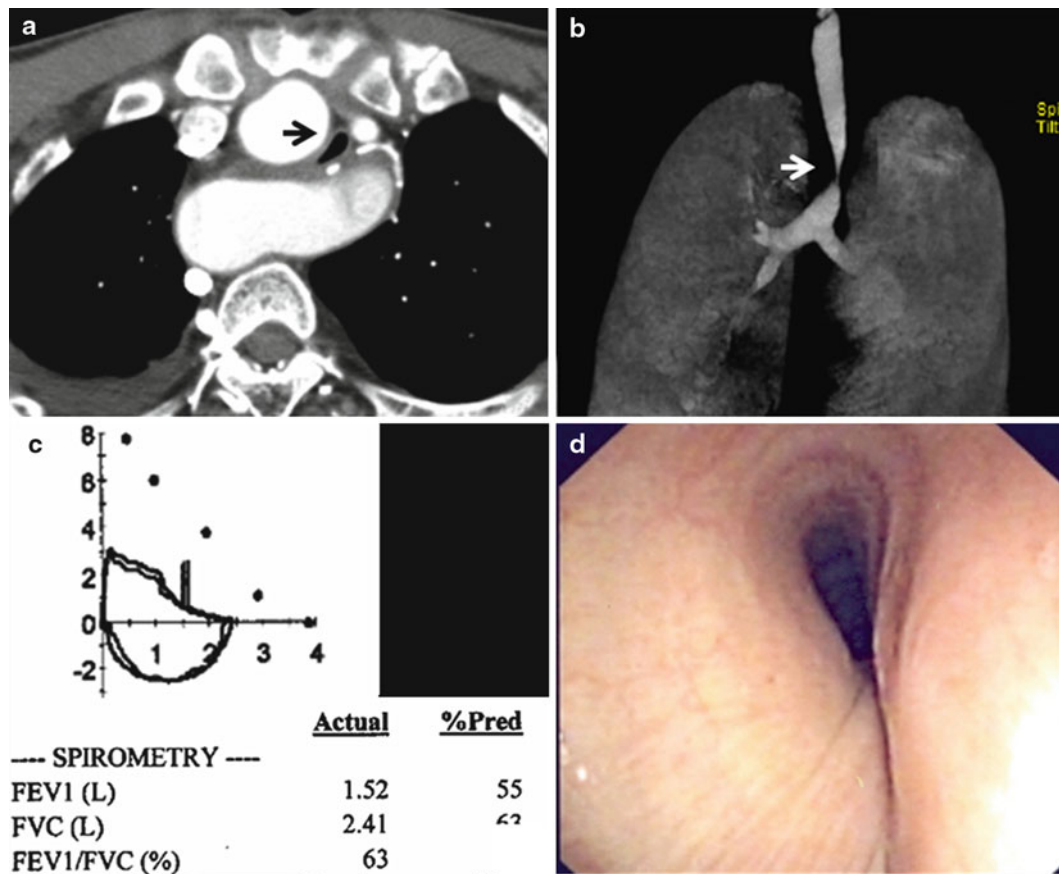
Evaluation of airway stenosis with (a) computed tomography, (b) three-dimensional reconstruction imaging, (c) spirometry, and (d) flexible bronchoscopy showing a mid-tracheal extrinsic compression due to a vascular sling
